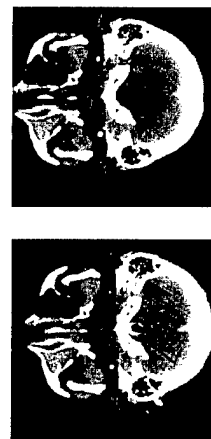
Initial Intraoperative CT scan. After initial resection, intraoperative axial CT scan revealed complete compression of the bony canal. The point of the fracture (long arrow) occurred from a fracture line by laminar and resection cavity (short arrow).
